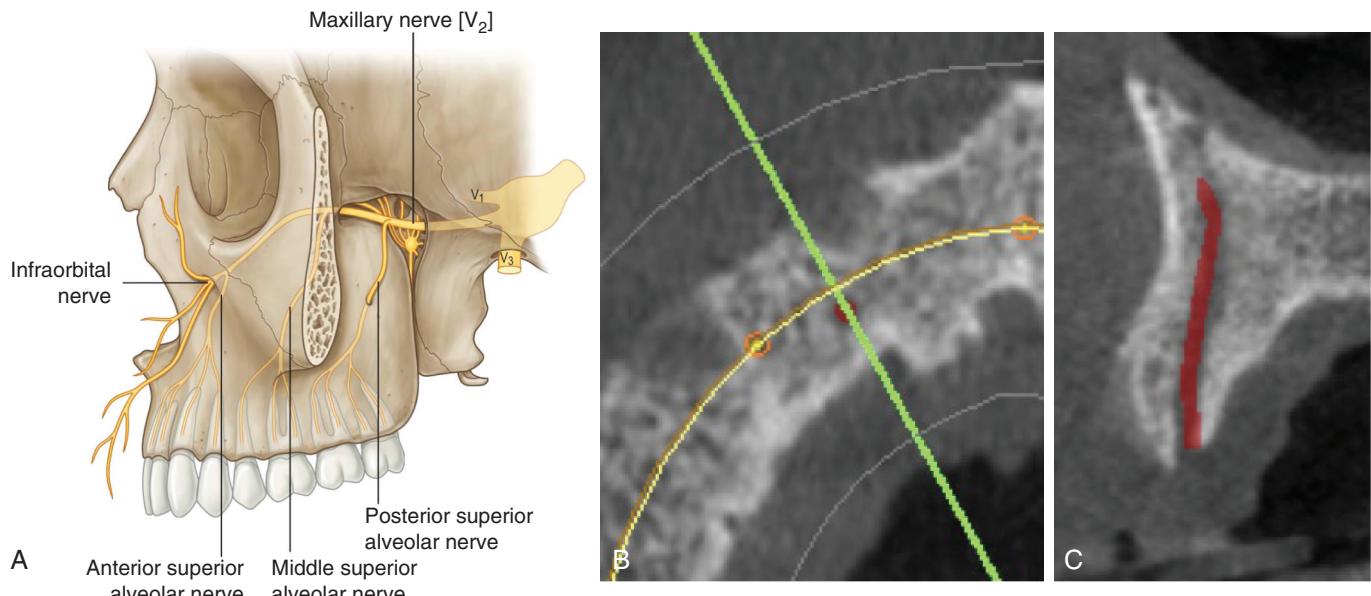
(A) Anterior superior alveolar nerve. (B) Canalia sinuosa is an anatomic variant leading to placement of implants into the canal leading to a soft tissue interface. Axial CBCT image showing location in center of residual ridge. (C) Cross-sectional CBCT image depicting the canalia sinuosa. (A, From Wells M: *Local and regional anaesthesia in the emergency department made easy*, Edinburgh, 2010, Churchill Livingstone.)
